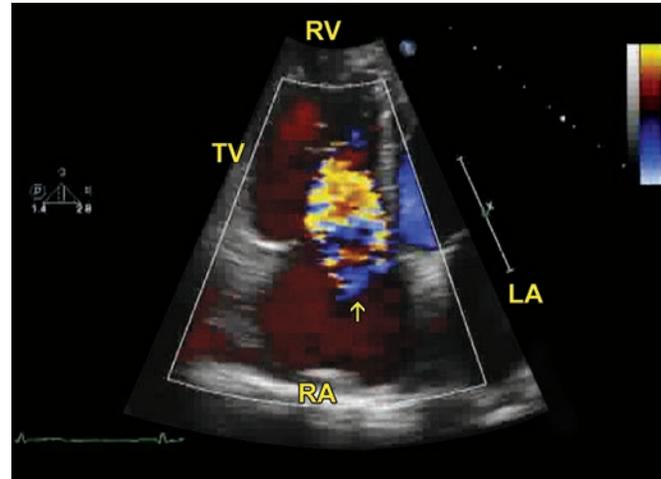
Apical 4-chamber view. Color Doppler shows significant TR (arrow).
